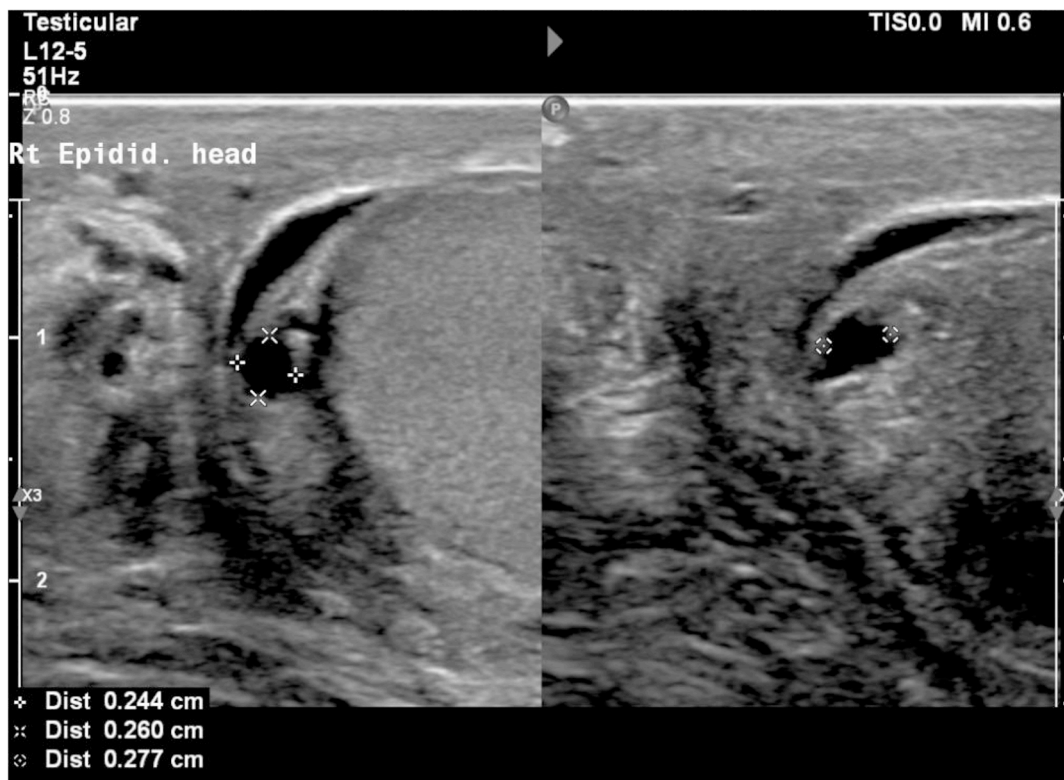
Ultrasound image of Epididymal Cyst containing evidence of Filariasis.
